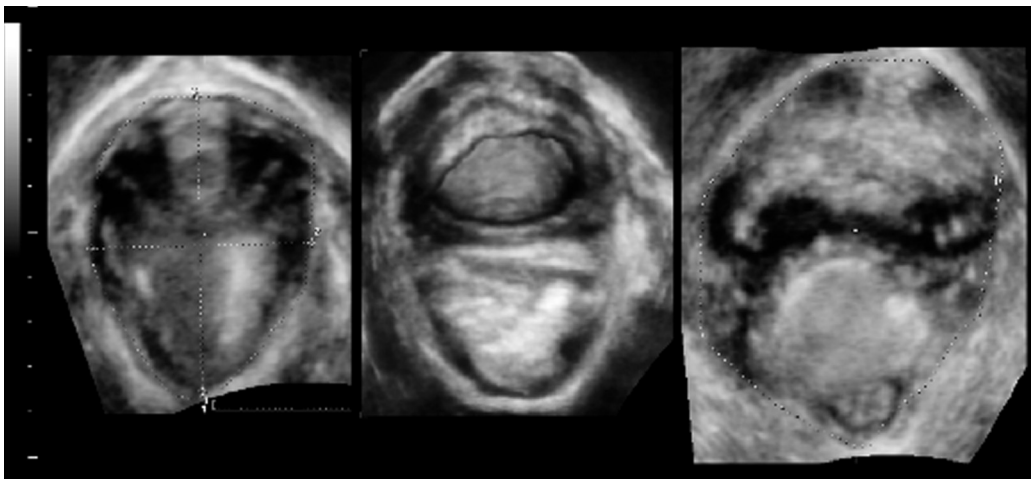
Three-dimensional pelvic floor ultrasound images in the axial plane showing mild (26.2 cm²) (a), moderate (34.4 cm²) (b) and severe (42.8 cm²) (c) hiatal ballooning on Valsalva manoeuvre in patients with symptomatic prolapse. Image (c) also shows the effect of a right-sided avulsion injury whereas (a) and (b) show a macroscopically intact (if excessively distensible) hiatus.
